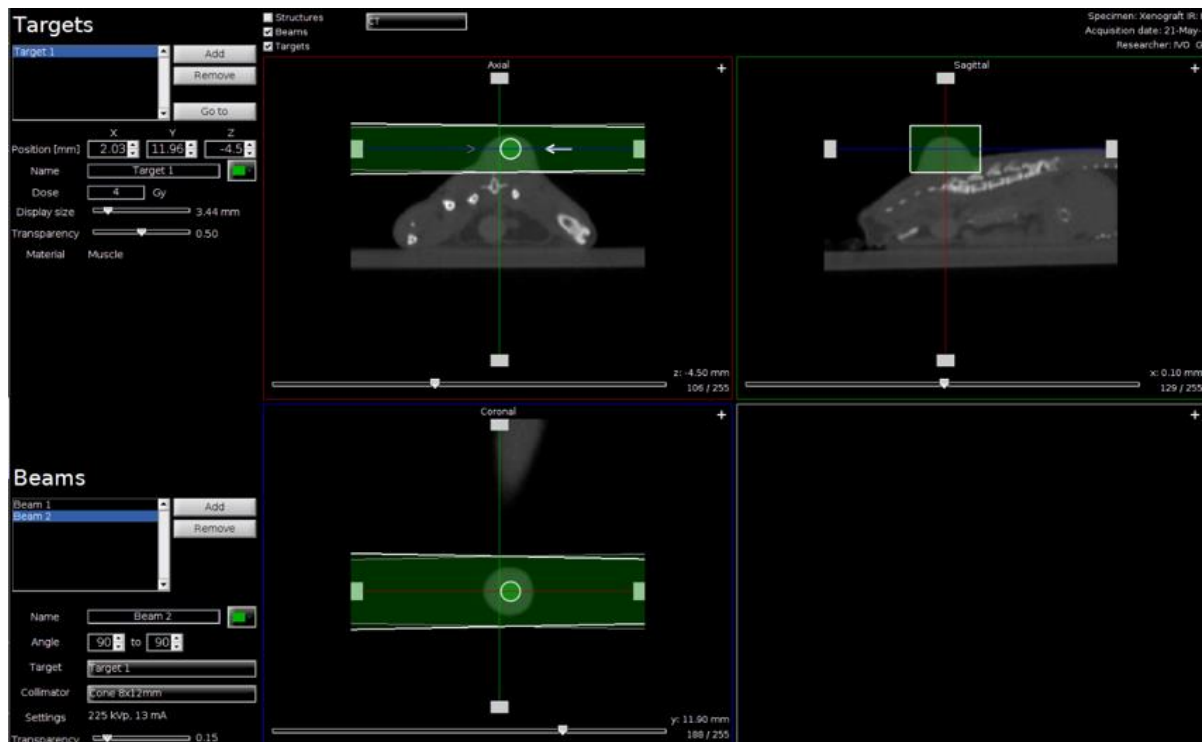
Example of a SmART treatment plan for xenograft irradiation using PXi. CT scans from sagittal, coronal and axial view. The irradiation beam is presented in green.
